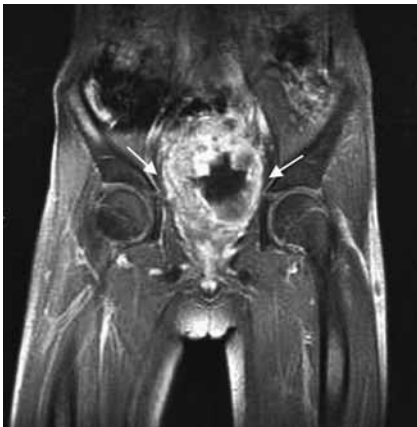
Coronal post-gadolinium T1-weighted fat sat image shows a large irregularly enhancing, centrally located pelvic mass (arrows).
